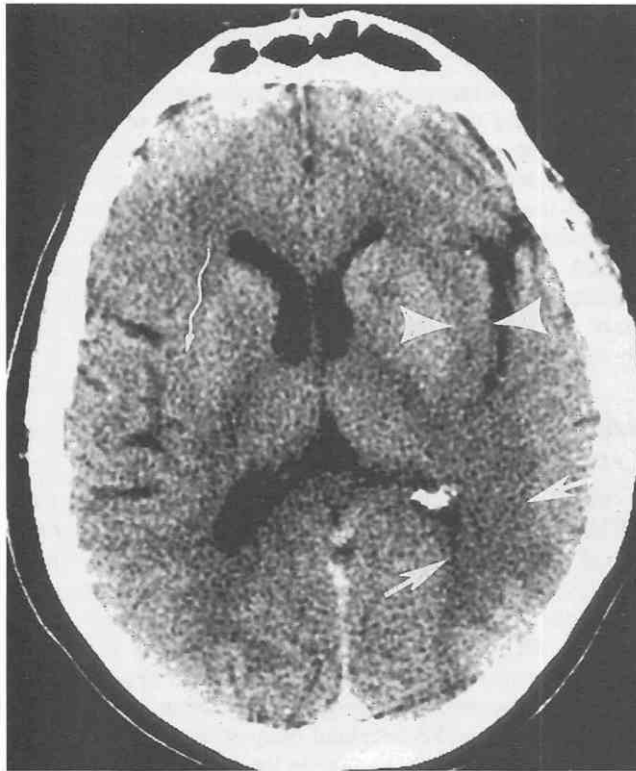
Loss of the insular ribbon. Unenhanced axial CT scan in a patient with acute right hemiparesis. There is decreased density with loss of distinction of the insular gray matter from the underlying external capsule (*large arrowheads*). Diminished density is also present in the posterior left temporal lobe (*arrows*). The right insular ribbon appears normal (*wavy arrow*).
